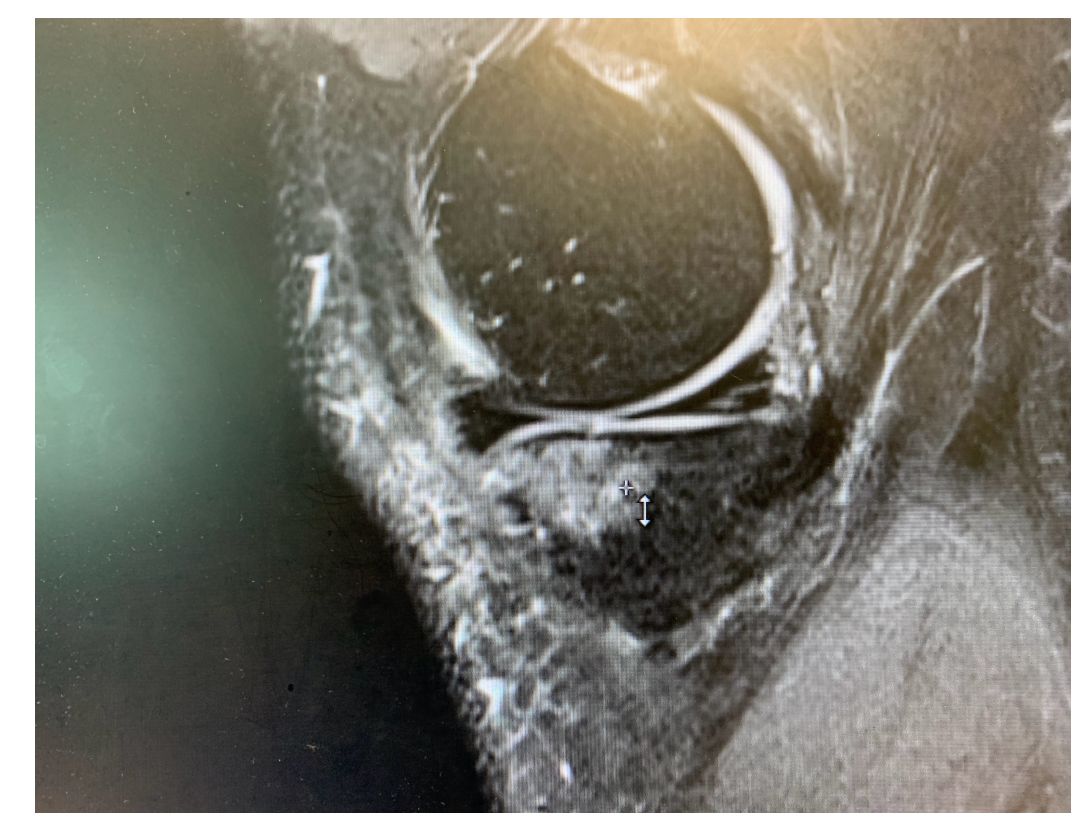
MRI image of BME from Lateral View- Case 1
